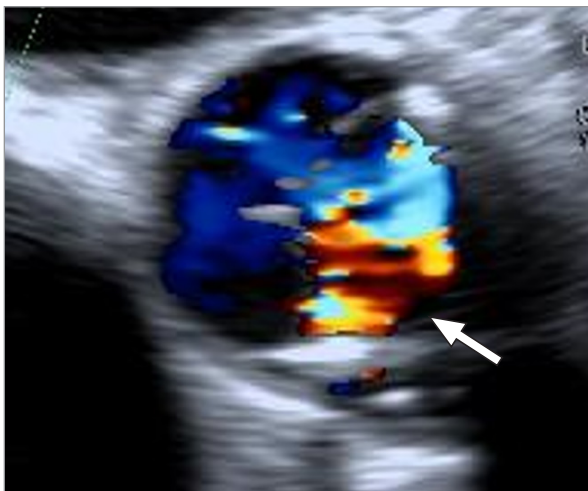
Preoperative transesophageal echocardiography in a short-axis view shows severe aortic valve regurgitation (arrow).
